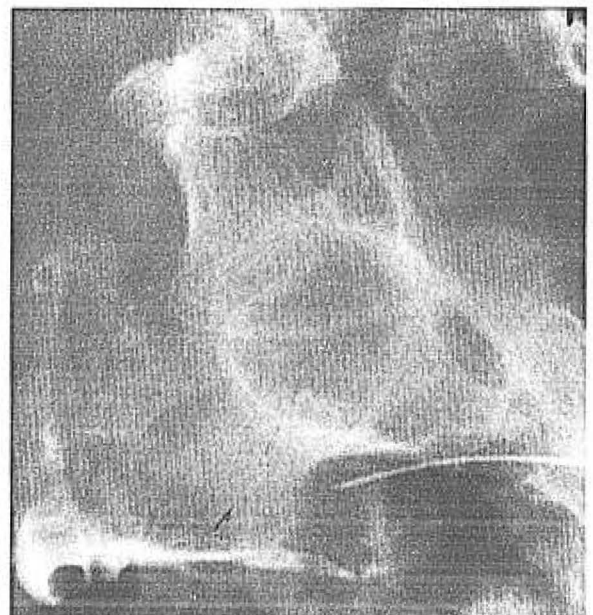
Arthrogram of the left sacroiliac joint with the patient in a right anterior oblique position. There is a ventral capsular tear and radiographic contrast surrounds the iliac vessels.
